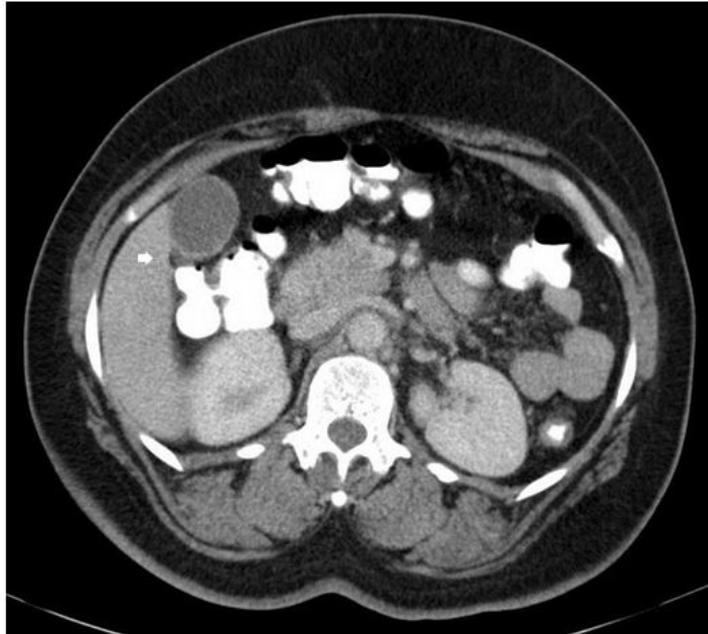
3 CT demonstrating partially calcified calculi with no evidence of gallbladder wall thickening or pericholecystic fluid. Arrow indicates the ectopic liver lobe.
